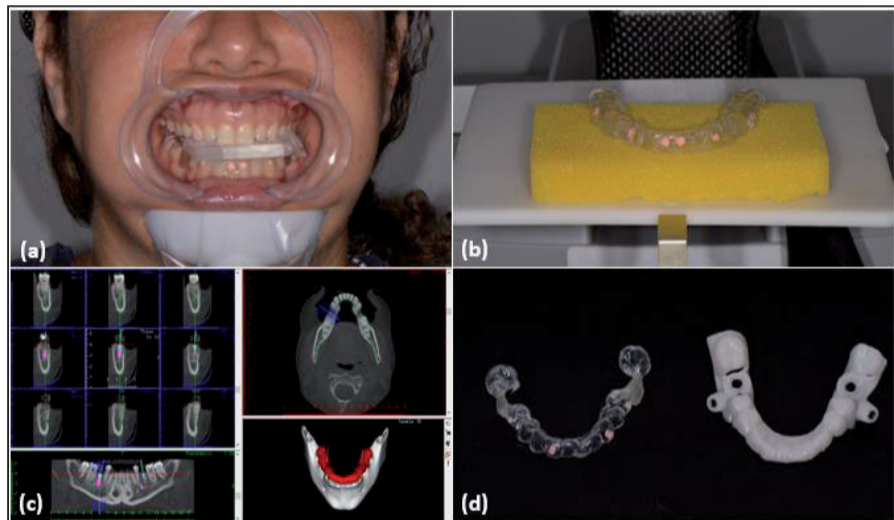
(a) Patient prepared to CBCT scanning; (b) CBCT scanning of the scan appliance alone; (c) virtual planning; (d) conventional surgical guide (left) and stereolithographic surgical guide (right).
